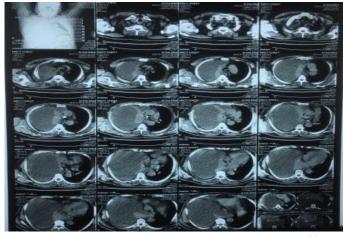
CT scan chest shows massive pleural effusion involving whole right hemi-thorax
